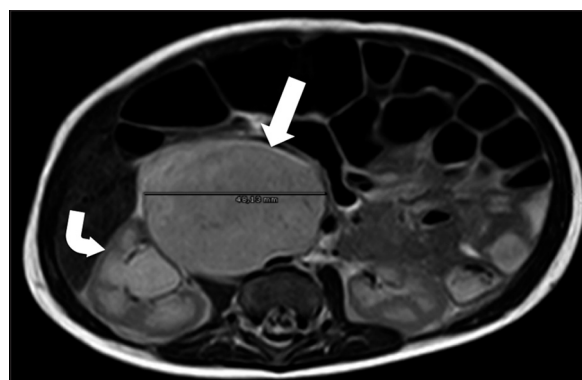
Abdominal magnetic resonance imaging. T1-weighted image with contrast. Axial image at the level of the lower renal poles. Well-defined solid retroperitoneal mass, right paravertebral, that crosses the midline. The lesion is slightly heterogeneous impregnated after the use of contrast (arrow). It has a mass effect on the right pyeloureteral region causing obstructive hydronephrosis (curved arrow). There are no signs of invasion of the spinal canal.
